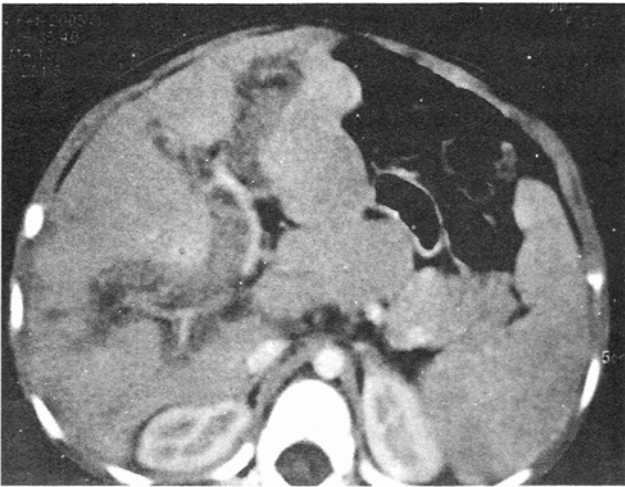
b. Contrast enhanced axial CT scan shows extensive periportal hypodensities ($HU \cong 23$ to -57) that correspond to hyperechoic bands seen on USG. There are occasional areas of fat densities within. Surrounding hypodensities make the portal vein branches stand out in contrast. The caudate lobe is significantly enlarged.
